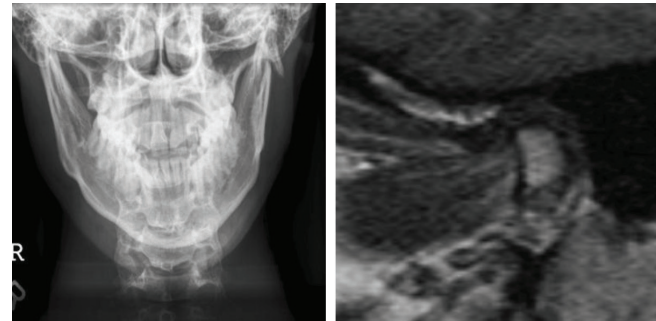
Plain x-ray (PA View mandible) showing fractured condylar segment with displacement; Figure-2: The closed-mouth position, the condylar head and disc show a normal condyle-disc relation and disc shape.
